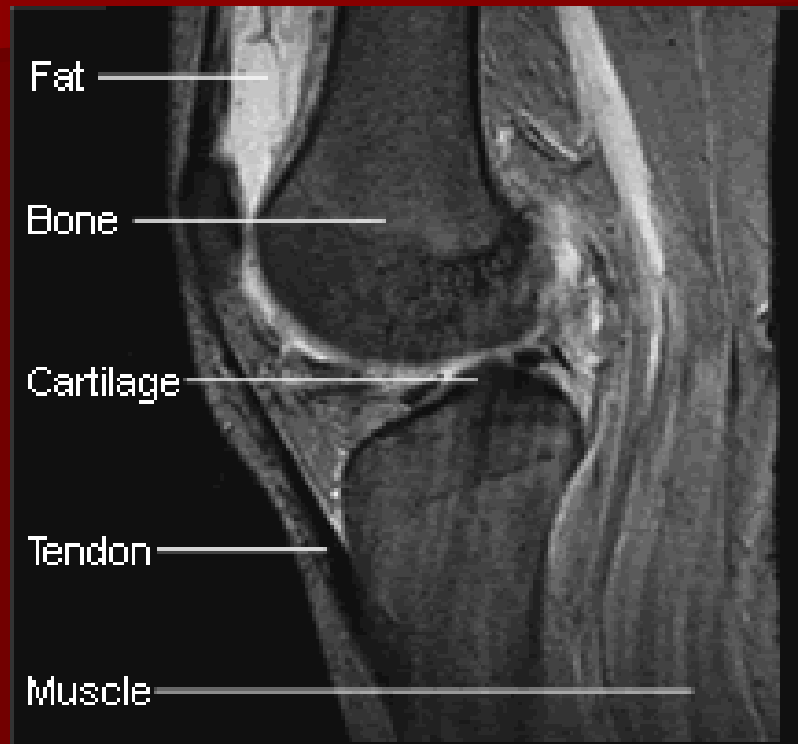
An MRI scan of the knee
